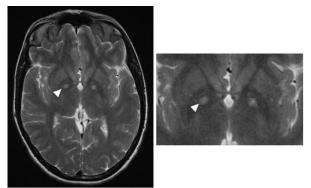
MRI brain for case II-I*. Bilateral T2-weighted signal hyperintensities were seen in the globi pallidi (white arrowhead)
